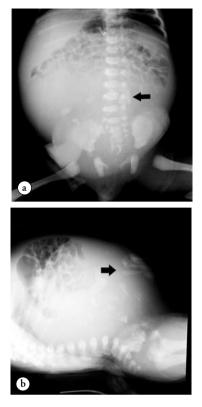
Abdominal x-ray. a) Supine and b) cross table lateral showing the abdominal pelvic soft tissue mass with a well differentiated elongated bone likely representing the femur (arrows).
